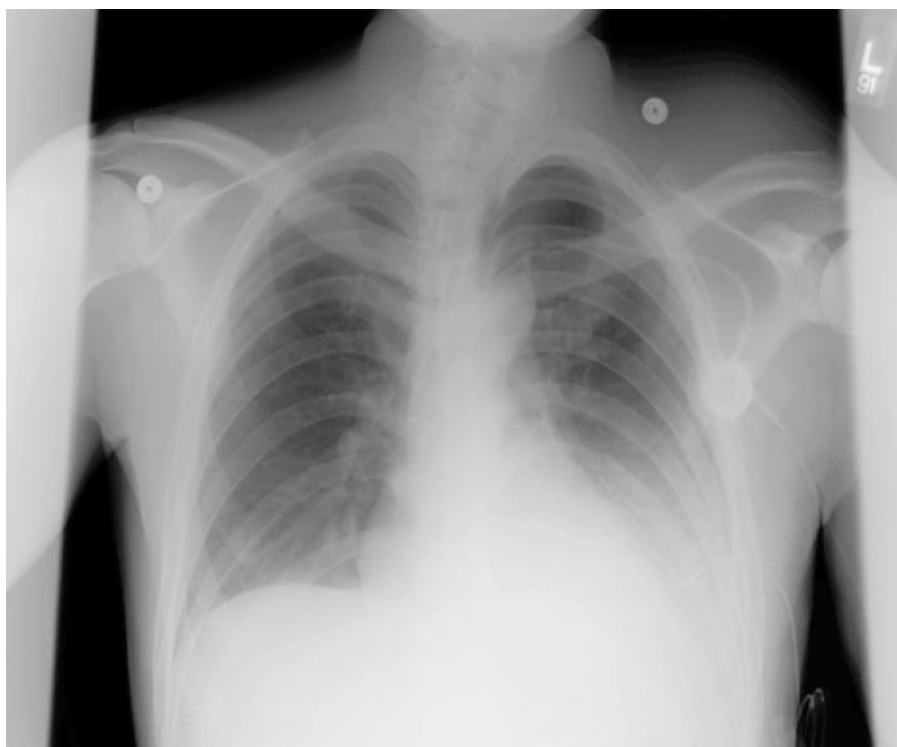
AP radiograph of the same patient as in figure 2 after the insertion of a PC and first drainage of 1,200 ml of bloody effusion. The PC can be seen first along the diaphragm and then along the left heart border.
